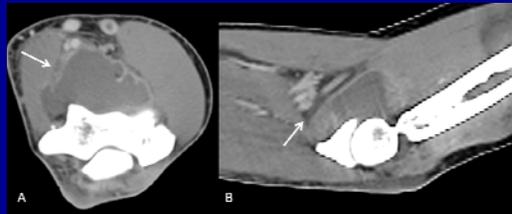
CT scan of a patient with brachialis syndrome. A: Axial view of distal arm demonstrating brachialis muscle swelling and central fluid attenuation consistent with intraoperative muscle necrosis. B: Sagittal view of the distal arm demonstrating brachialis muscle swelling and necrosis overlying the coronoid process.
